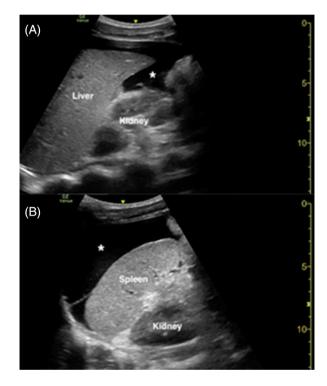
Point-of-care ultrasound demonstrating intra-abdominal free fluid (asterisk) in the caudal liver edge of a longitudinal right upper quadrant view (A) and in the subphrenic space of a longitudinal left upper quadrant view (B)
